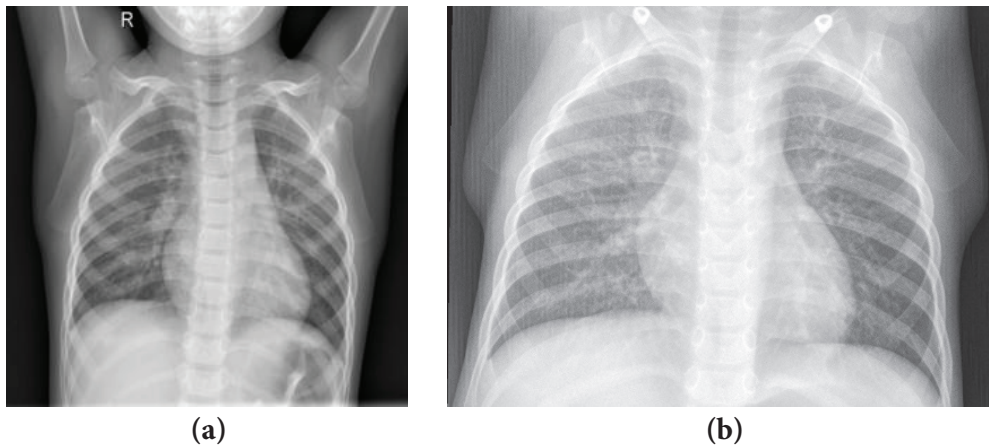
Chest X-ray images (a) Healthy (b) Pneumonia
